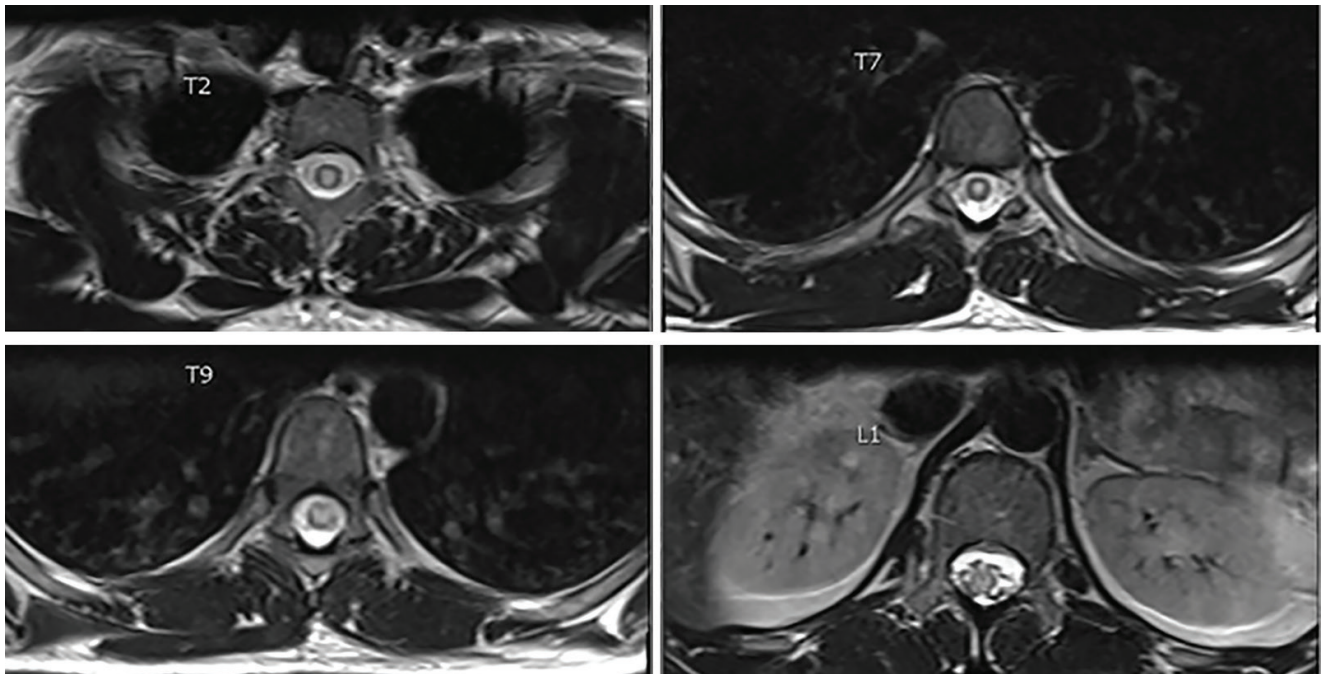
Axial T2 postcontrast MRI showing central cord hyperintensity and enhancement of T2 through L1.
